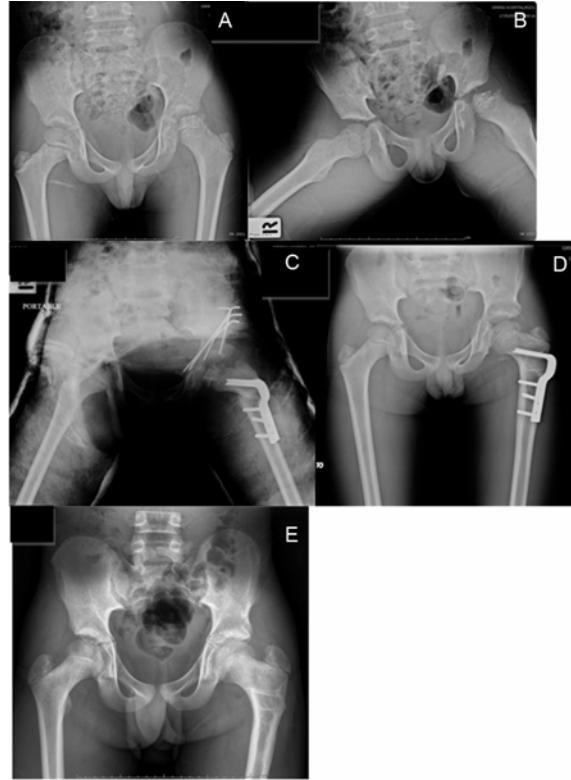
A) Show Perthes Lt. hip in 9 years old boy with Catterall III, B) AP radiograph with abduction 20 degrees shows inadequate containment of femoral head, C) Femoral varus osteotomy combine with Salter osteotomy, D) At follow-up 1 year with good coverage, E) At follow-up 4 years with good coverage and spherical shape of femoral head
